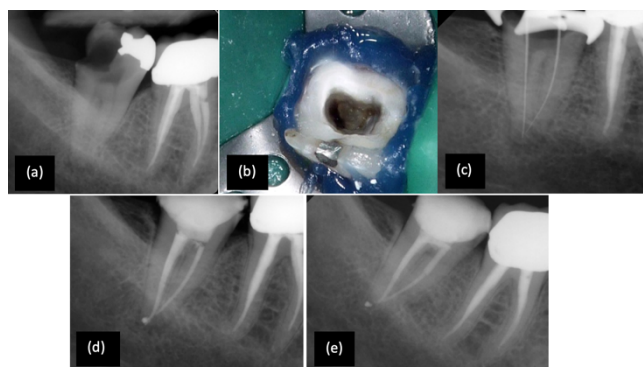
A 55-year-old female who attended the endodontics clinic complained of severe pain in the lower right area. Tooth #47 was diagnosed as symptomatic irreversible pulpitis with symptomatic apical periodontitis. RCT was performed using XP-endo system (a)Pre-operative radiograph. (b) Access cavity showing C-shaped canal configuration. (c) Working length determination. (d) Post-operative radiograph. (e) 2 years follow up, RCT was successful.
